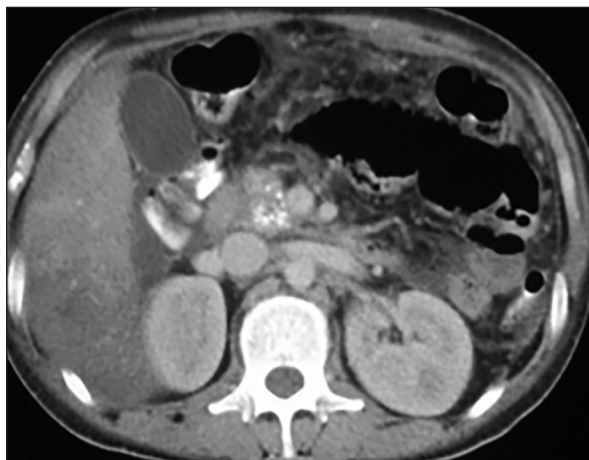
CT abdomen: Calcification in the uncinata and head of the pancreas
